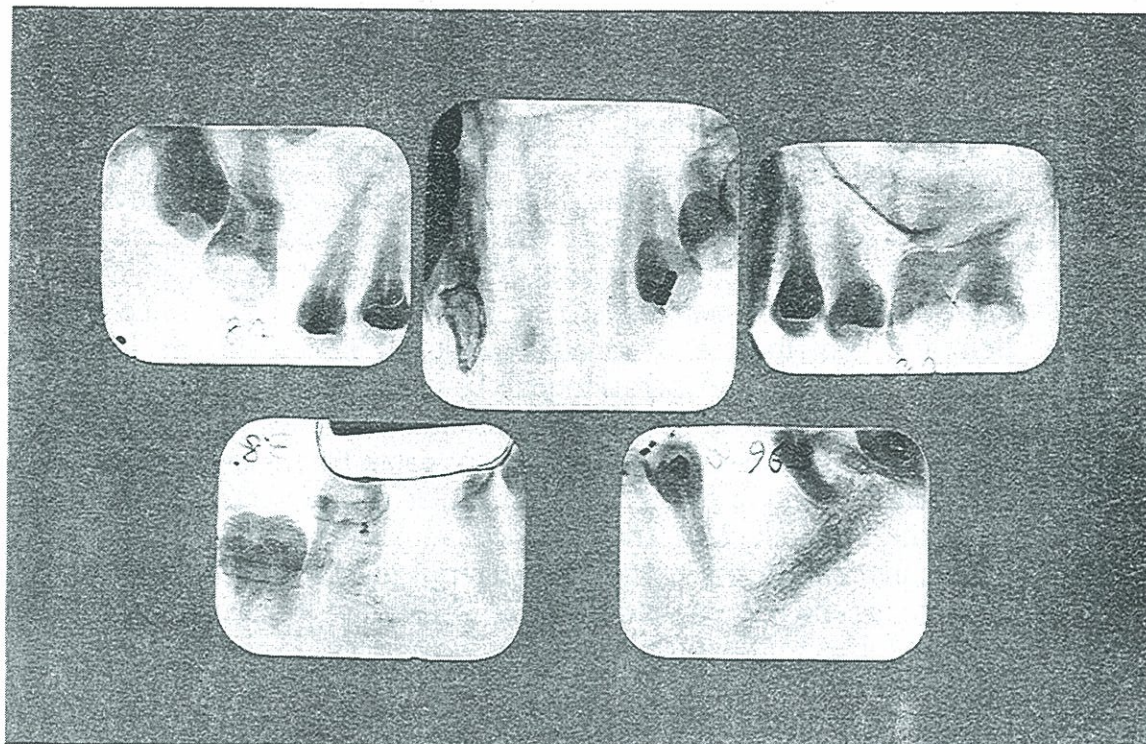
ROENTGENOGRAPHIC APPEARANCE OF TEETH OF CASE NO. 385.
